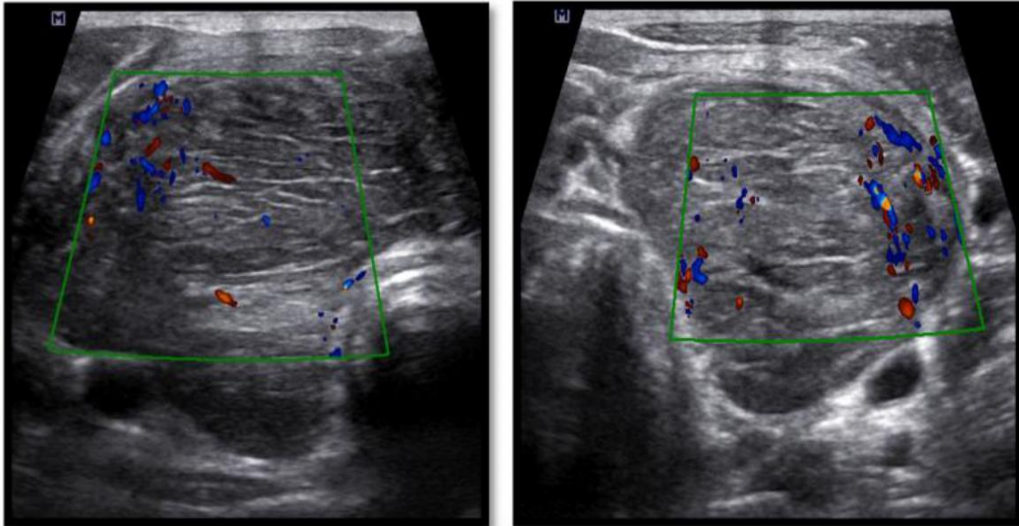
Color Doppler in the same patient showed reduced parenchymal vascularity, FNAC showed features of Hashimoto's thyroiditis.
